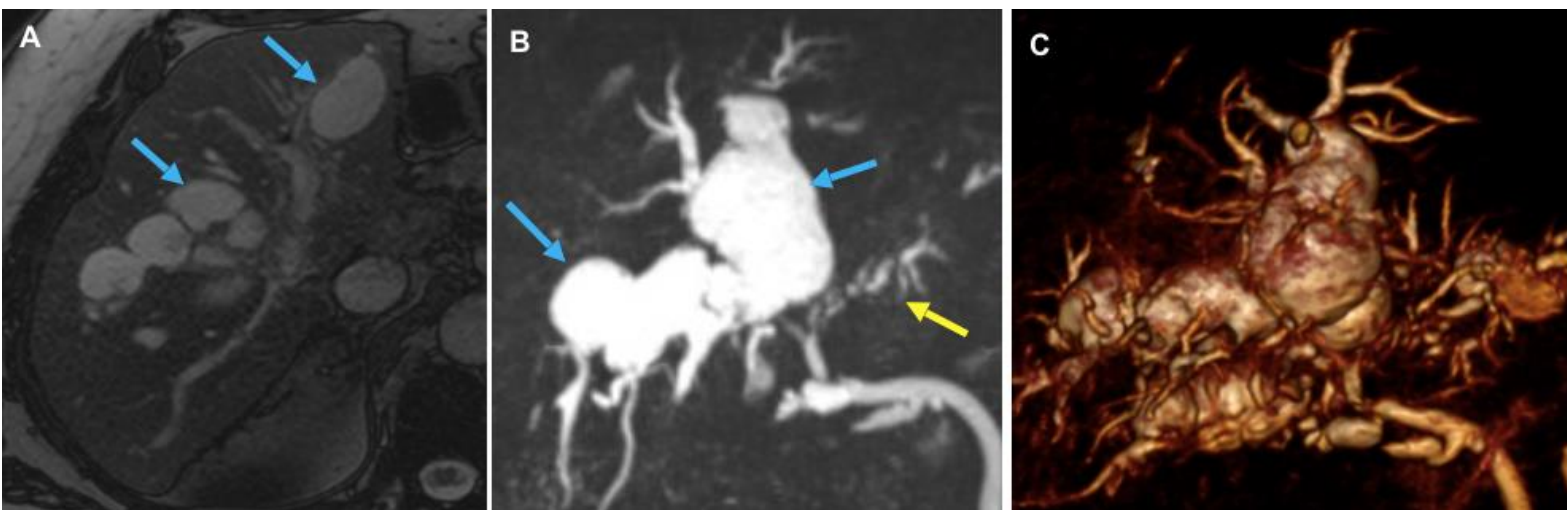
58-year-old male underwent a liver transplant for hepatic sarcoid. Noticed to have worsening LFTs at 6 weeks post-op. Initially investigated with ultrasound, which showed areas of cystic change within the liver. (A, B, C) MRCP T2* and MIP reconstructions shows cystic dilatation of the intrahepatic bile ducts (blue arrows) with relative sparing of the peripheral ducts. Findings are of multiple intrahepatic bilomas and larger bile lakes secondary to an ischaemic cholangiopathy causing breakdown of the affected ducts. Note the irregular left sided intrahepatic bile ducts (yellow arrows). The hepatic artery was found to be thrombosed and a re-graft was required.
